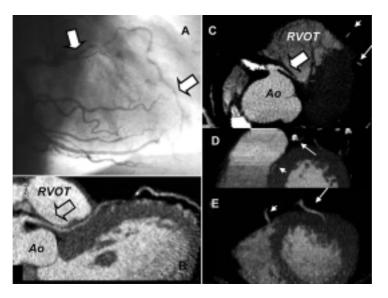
A: coronary angiogram in the right anterior oblique projection showing the anomalous origin of the long left anterior descending coronary artery (LAD) (arrows) from the proximal right coronary artery. B: a curved multiplanar reconstruction from the multislice computed tomography examination showing, in more detail, the anomalous origin of this vessel and the abnormal path of the long LAD (arrow) that runs between the aortic root (Ao) and the right ventricular outflow tract (RVOT). C: transverse multislice computed tomography image depicting the origin of the long LAD (large arrow) that passes between the Ao and the RVOT. At the same level it is possible to recognize, in the anterior surface of the heart, both the long LAD (short thin arrow) and the short LAD (long thin arrow). D: coronary multiplanar reconstruction showing the intramyocardial course of the short LAD (long thin arrow) that presents heavy parietal calcifications. E: coronary multiplanar reconstruction showing the long LAD (short thin arrow) that runs in the anterior interventricular groove and the short LAD (long thin arrow) that is located slightly to the left.
